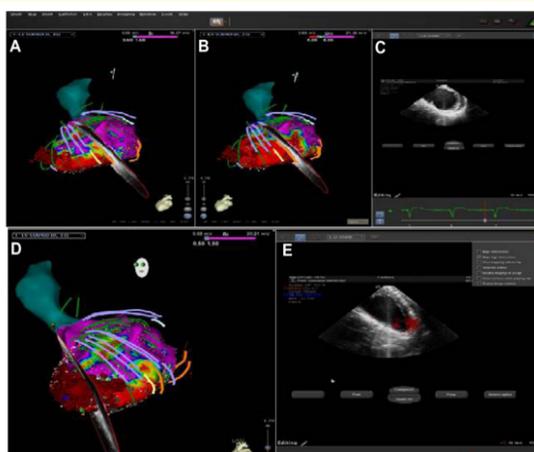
Integration of intracardiac echocardiography with ventricular electroanatomic mapping. (A, B, D) integration of intracardiac echocardiography with bipolar and unipolar left ventricular electroanatomic mapping. (C, E) intracardiac echocardiographic views of all left ventricular layers. ICE gives an important support during ablation procedures with information about the contact between the mapping/ablating catheter and the myocardial tissue, indicating the sites where RF energy has been delivered (red tags). Comparison with electroanatomic maps may show the anatomical features of areas of potential interest and provide a real time continuous monitoring and surveillance of potential procedural complications. (ICE, intracardiac echocardiography; RF, radiofrequency).
